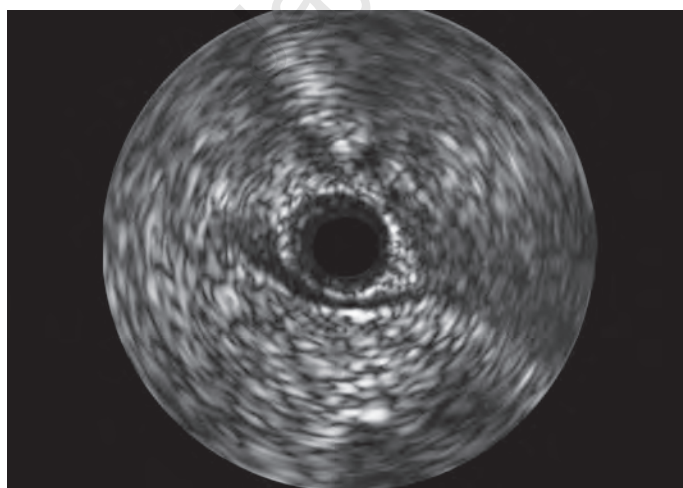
Intravascular ultrasound "half-moon" sign (Echolucent area noted between the bridged coronary segment and the epicardial tissue).
